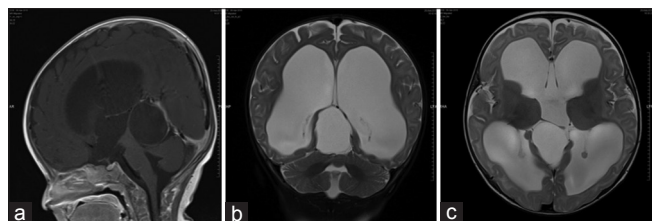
Magnetic resonance imaging brain (a) T1 sagittal view (b) T2 coronal view, (c) T2 axial view showed a large pineal region arachnoid cyst measuring 2 cm × 2.8 cm × 3.2 cm in dimensions with secondary significant ventricular dilatation and hydrocephalus
